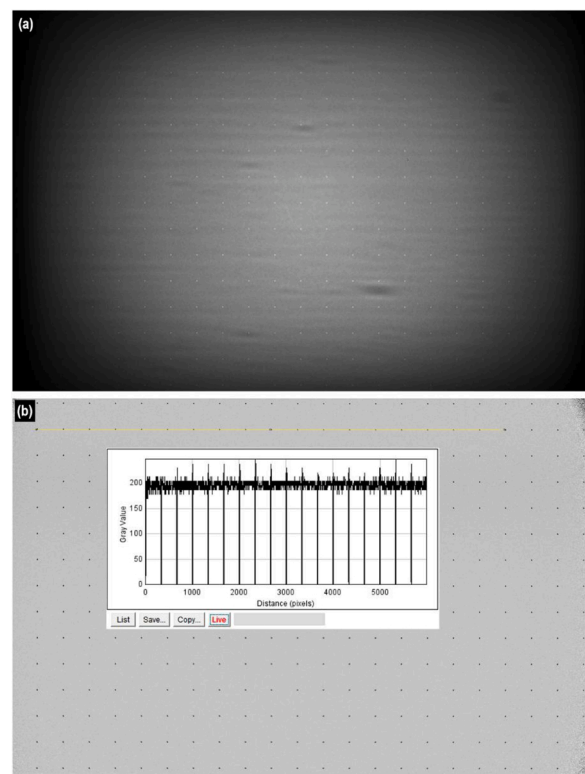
X-ray images of the aluminum plate chart with the pattern of aligned holes.
